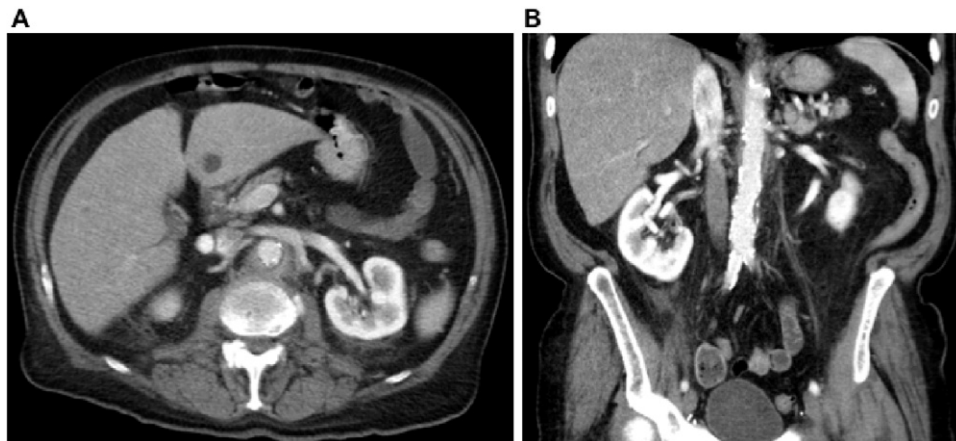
Axial (A) and coronal (B) images from the patient's computed tomography (CT) scan of the abdomen and pelvis on admission that showed soft tissue thickening of the aorta just below the level of the renal arteries with mural thrombus and surrounding fluid.
